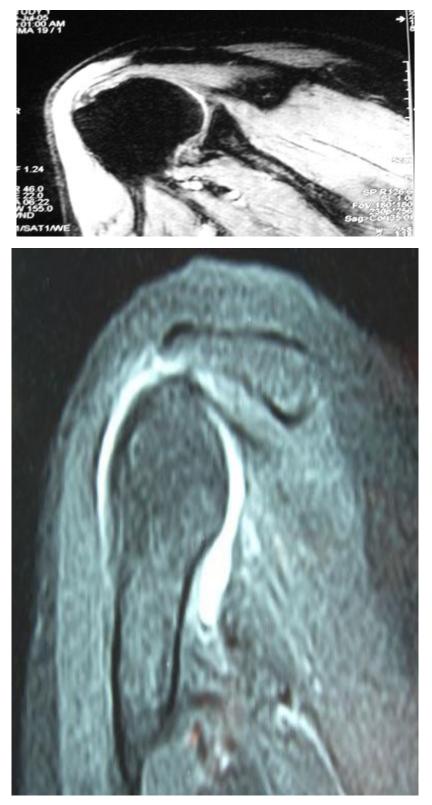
MRI image showing type III acromian with reduced acromio-humeral distance & glenohumeral joint effusion
